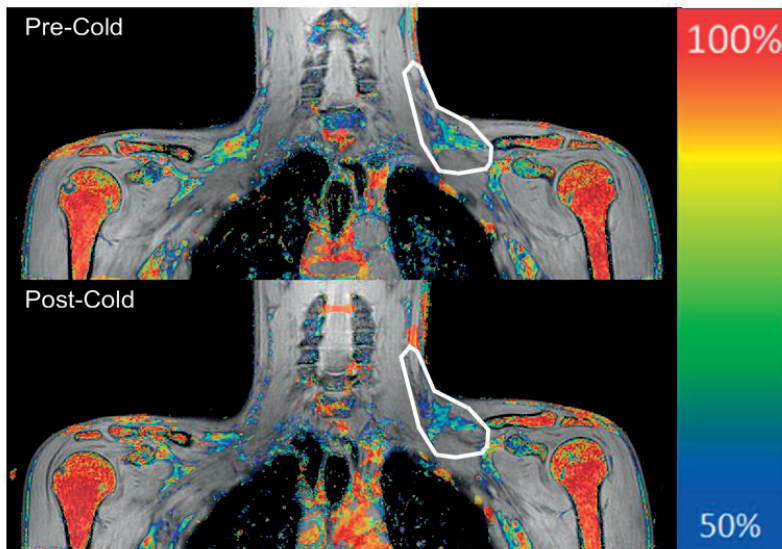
Region of interest drawn on the MRI scan. Example of supraclavicular region of interest drawn on MRI scan before and after cold exposure.
